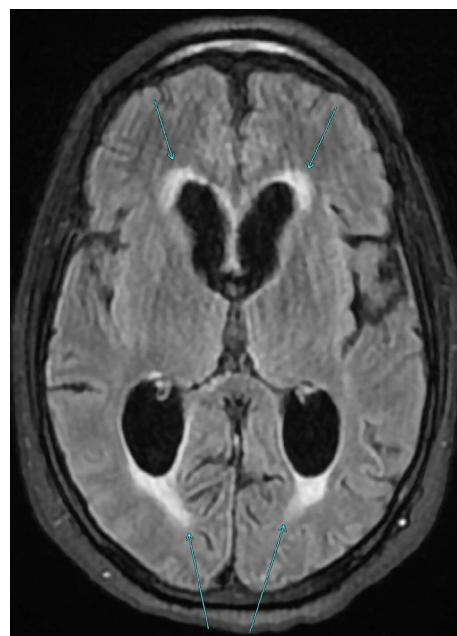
T2 FLAIR axial brain MRI showing ventricular system dilatation with pachymeningeal enhancement, and no evidence of PRES.
